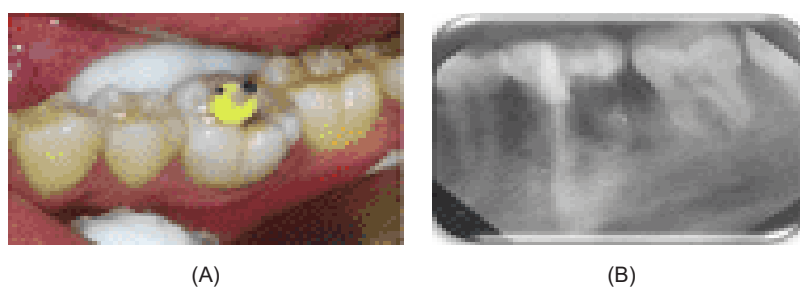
(A) Fitting of prefabricated fiber post for tooth 36; (B) Periapical radiograph of the cemented prefabricated fiber post
